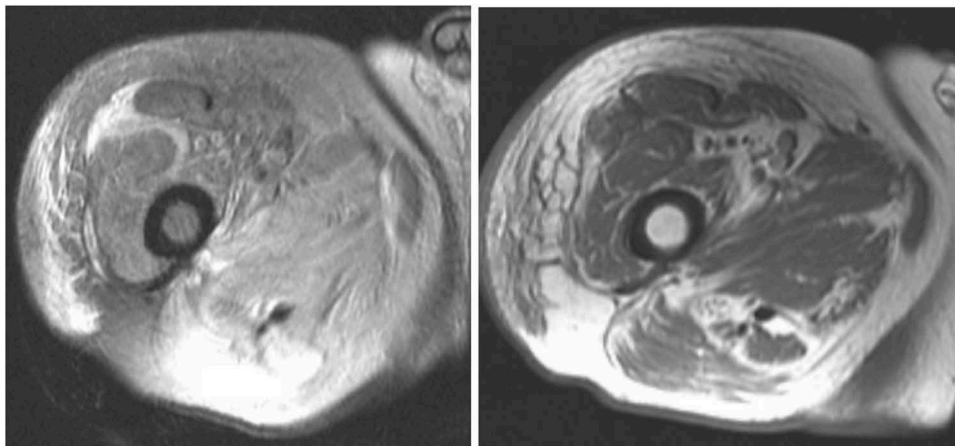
MRI of right thigh axial T1 & T2 with fat suppression showing extensive edema of the right thigh musculature, suggestive of diffuse myositis.
